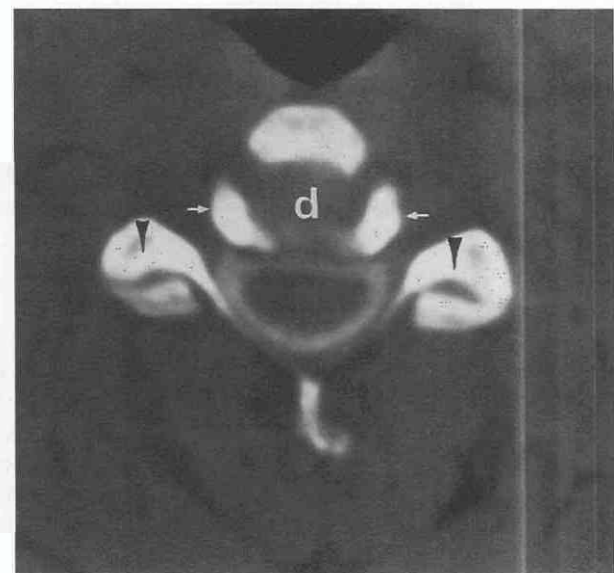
Cervical postmyelogram CT scan. The uncovertebral joints of Luschka are indenting the posterolateral disk (d) margins (arrows) (see Fig. 22-41). Note also the near-horizontal orientation of the facet joints (arrowheads) (see also Fig. 22-41).
